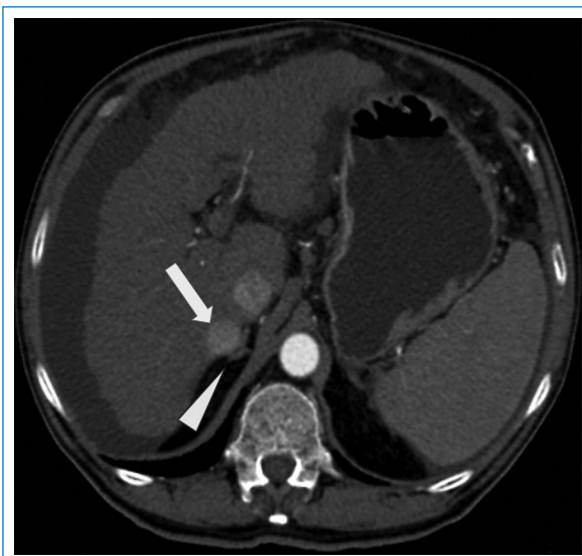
Abdominal computed tomography in the arterial phase, showing a hepatocellular carcinoma (arrow), contiguous to the right adrenal gland (arrowhead). A hypertensive crisis occurred during the thermal ablation procedure.
